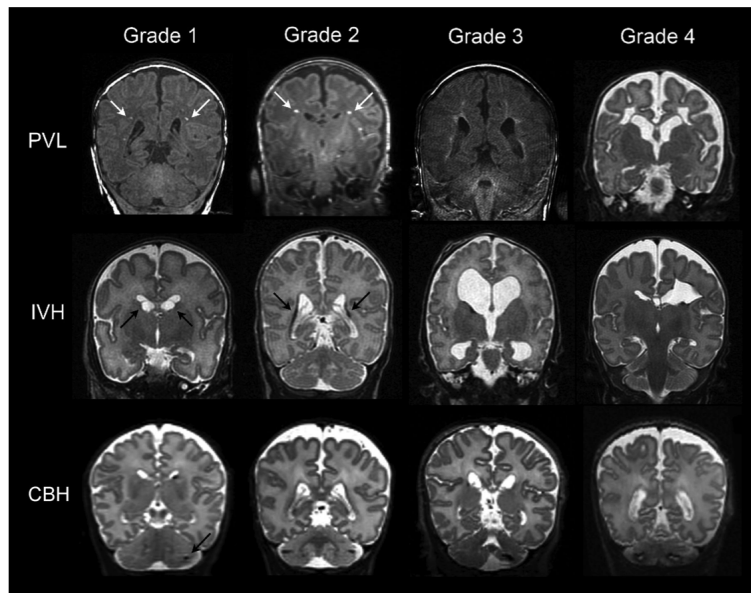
Classification of brain injury using representative T1W and T2W MRI of each grade of PVL, IVH and cerebellum hemorrhage (CBH) [72].
